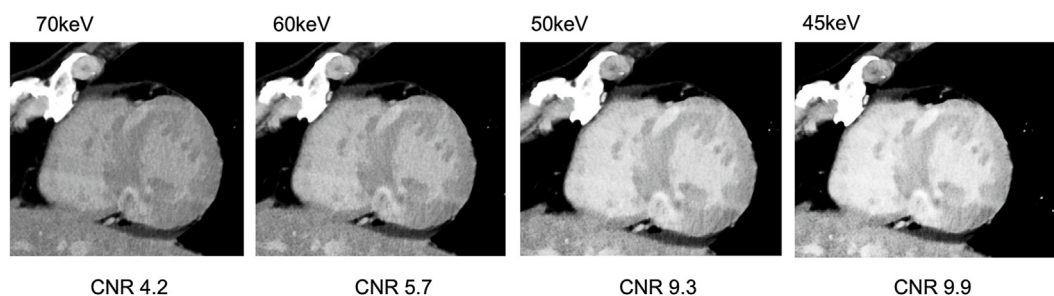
LE in a patient with hypertrophic cardiomyopathy obtained with a dual-source photon-counting detector CT. Abnormal LE was observed at the right ventricular-left ventricular junction. Even in the lower monochromatic energy range, there is an improvement in contrast-to-noise ratio due to increased iodine contrast effect without an increase in noise. LE, late enhancement; CT, computed tomography; CNR, contrast-to-noise ratio.
